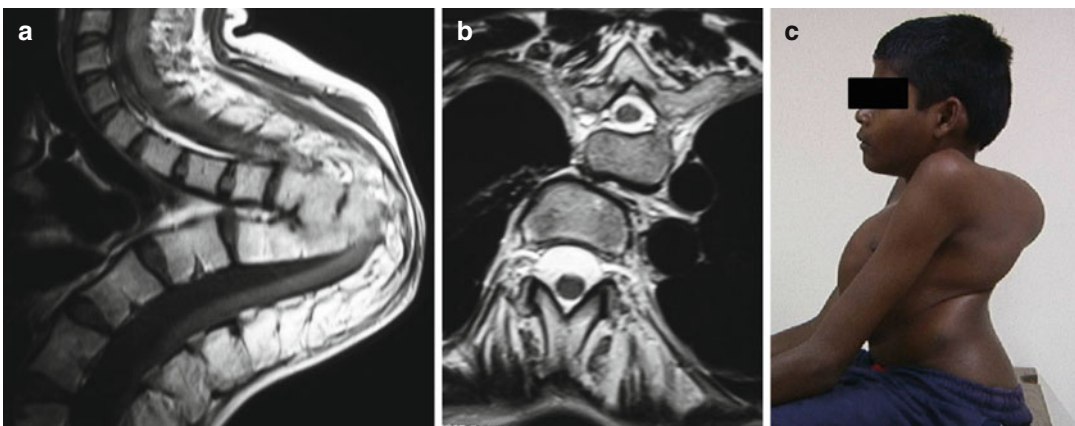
Buckling collapse due to neglected tubercular kyphotic deformity in a child. The sagittal MRI of spine shows buckled spine with two long spinal segments lying on each other (a). The spinal cord is stretched and compressed at the apex of the kyphosis. The axial MRI image
